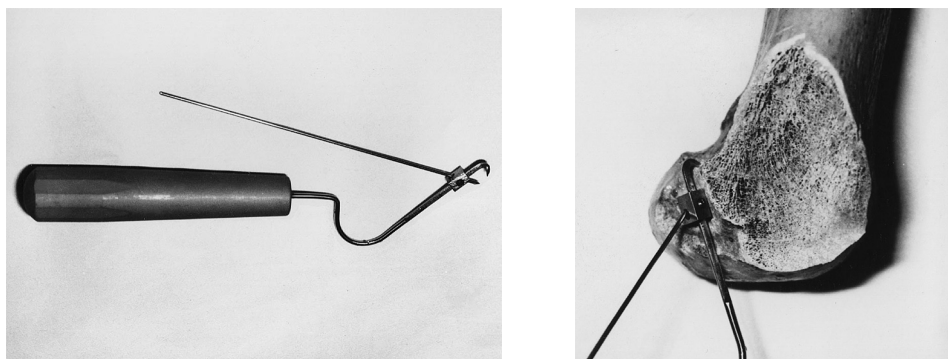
a) The adjustable aiming device has a sliding guide for a Kirschner wire, which is positioned at the distance measured on preoperative radiographs; b) The hook of the guide has to be positioned behind the posterior femoral cortex. (With kind permission from Springer Science+Business Media: Milankov and Miljkovic, 2000) [60]
